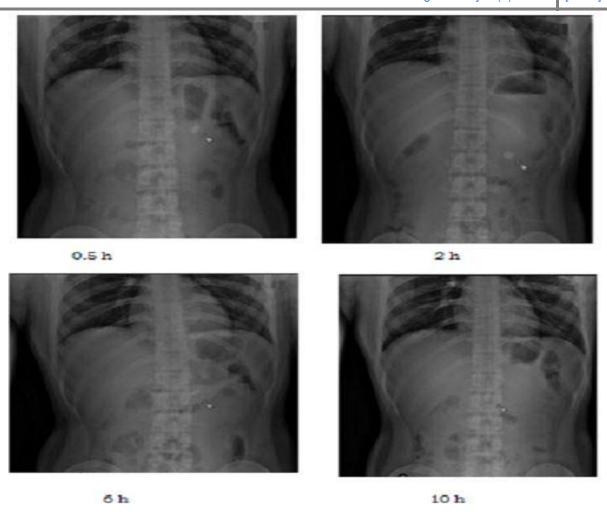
9 Radiographic Images of a BaSo<sub>4</sub> loaded Lafutidine mucoadhesive tablet (F 22) in the stomach
